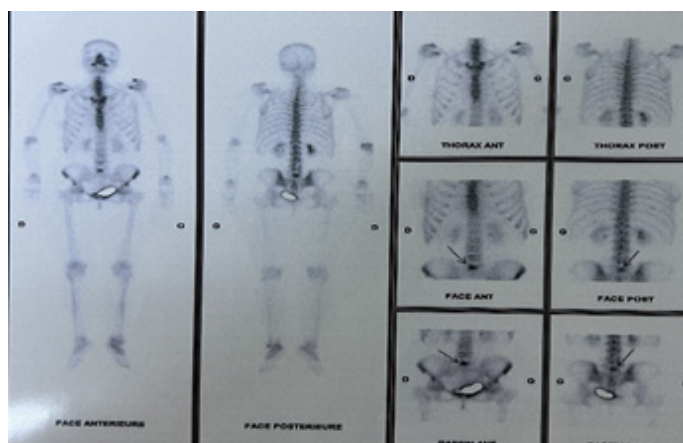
Initial bone scintigraphy showing a L5 bone lesion.
